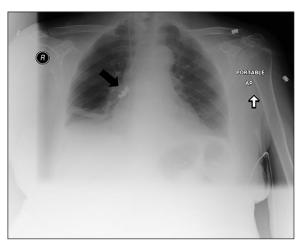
Portable antero-posterior chest X-ray postsurgery, note the foreign body in the right middle lobe (black arrow)
